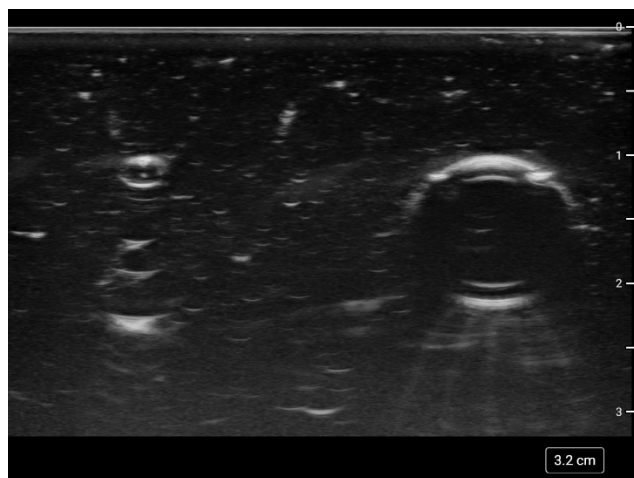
Unlabeled interscalene ultrasound sonoanatomy image with embedded anatomic structures
